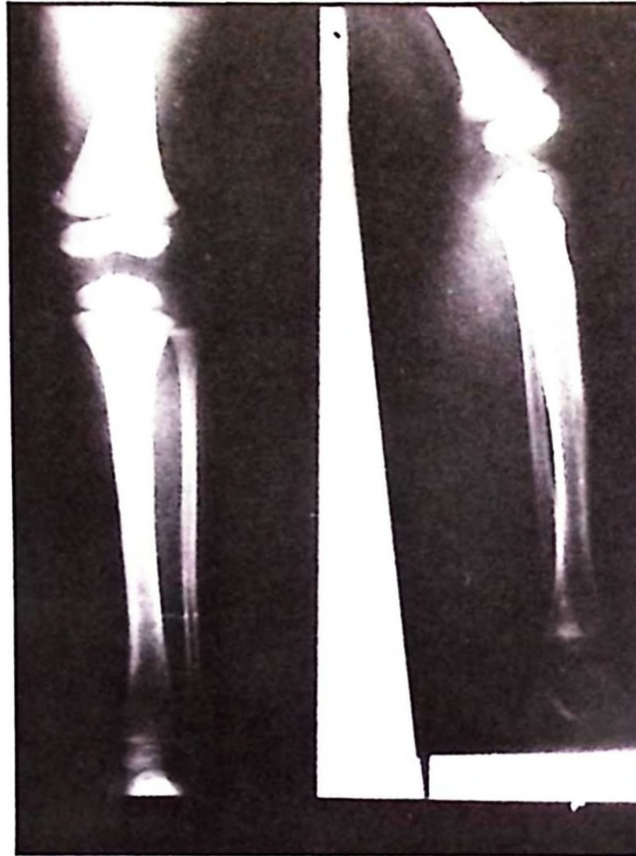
Anteroposterior and lateral roentgenogram of lower extremities (after treatment). No lytic lesion is present.
